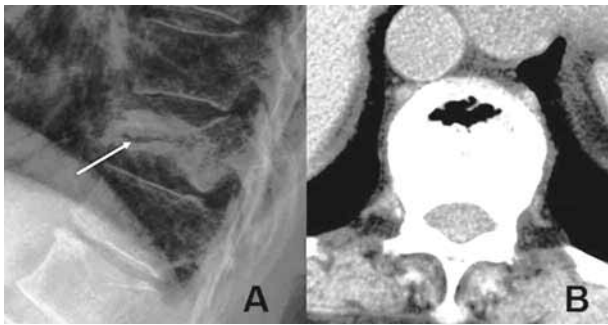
A : plain lateral radiograph showing an intravertebral vacuum cleft as a transverse, linear radiolucent area (arrow) ; B : CT-scan : same.
